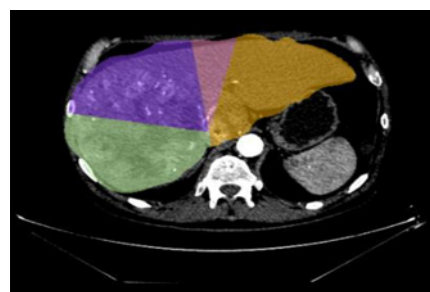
Remnant liver volume: arterial-phase CT scan in axial plane of abdominal cavity showing computed functional volume of liver segments.
